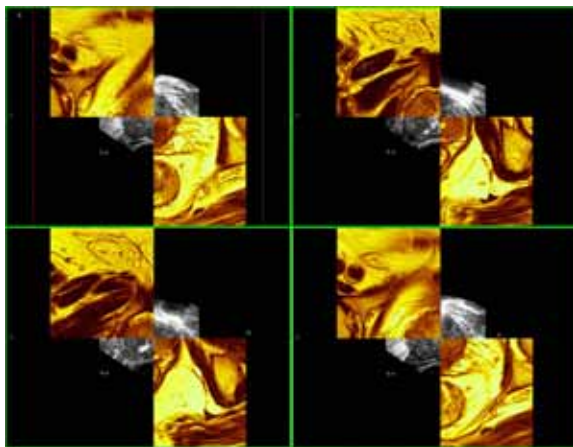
Automatic U/S & MRI registration
